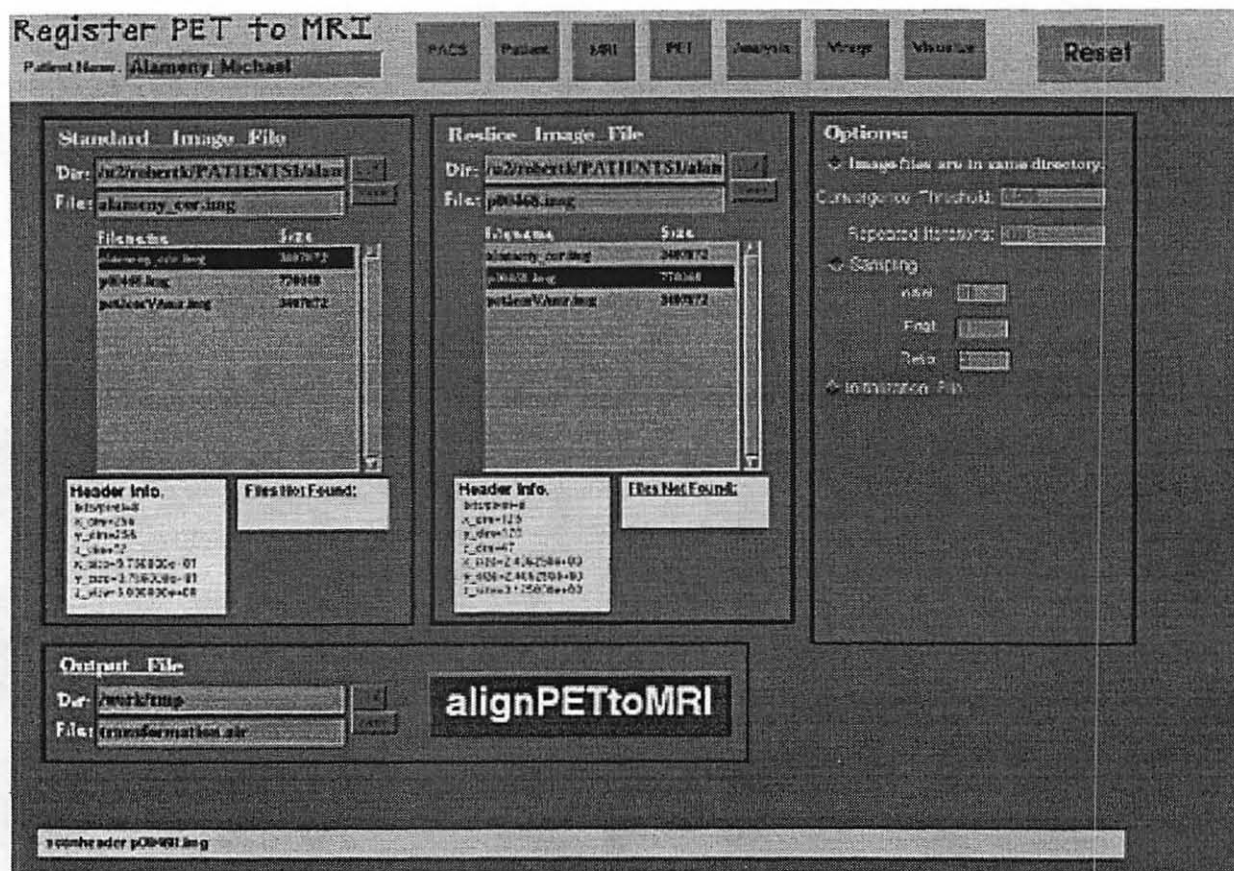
A screenshot taken from the multimedia PACS workstation showing the registration of PET to MRI.
